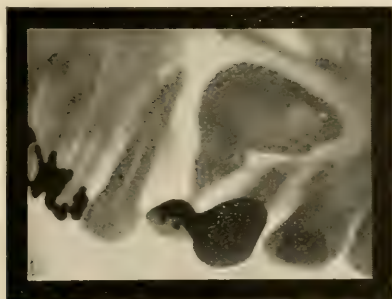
Bismuth paste injected into fistulous opening just above the first bicuspid dummy and nearly filling a very large abscess cavity. (Radiograph by Ream, of Chicago.)
